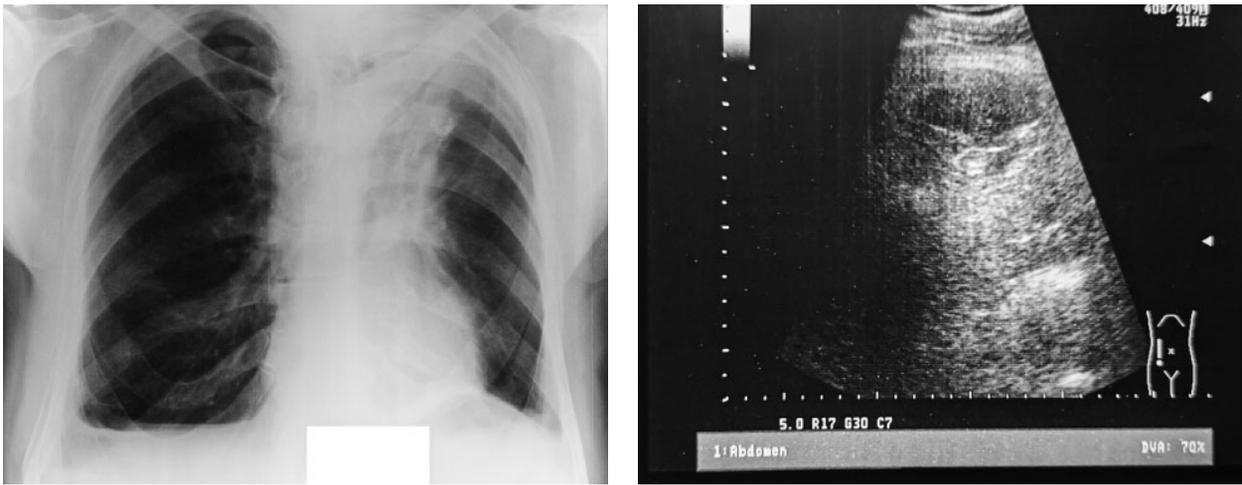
Chest X-ray and ultrasound of the left side along the posterior axillary line (20 ml of encapsulated liquid) dated 5 March 2024.
